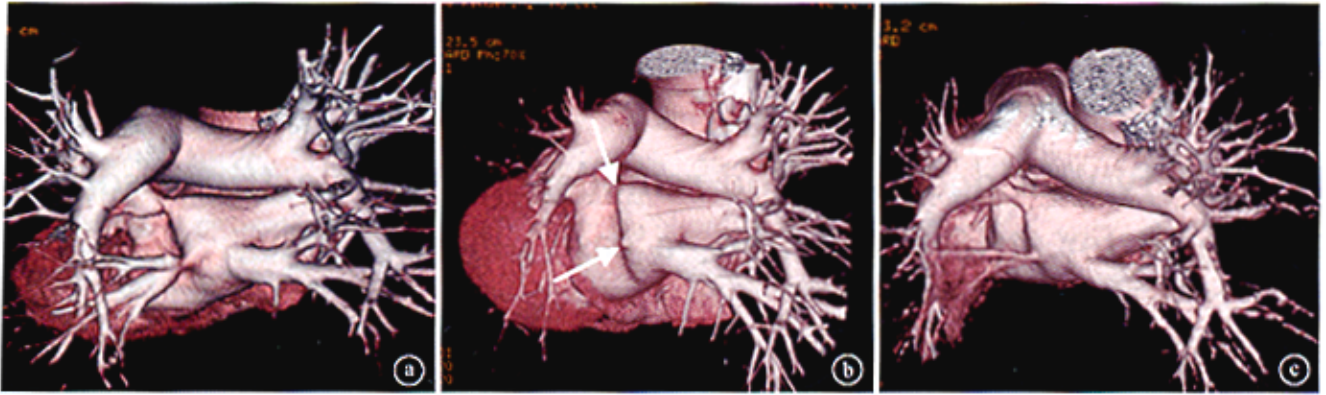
This chest computed tomogram shows (a)stenosis of the left pulmonary veins 13 months after the initial ablation , (b) occlusion totally of the left pulmonary veins ,(c) occlusion removed after surgery intervention.
